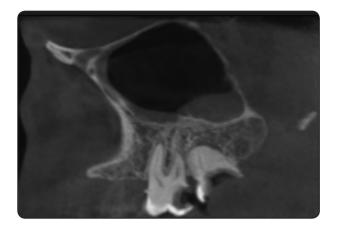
Preoperative CBCT showing badly decayed maxillary second molar to be extracted and its relation to the sinus and adjacent structures.
